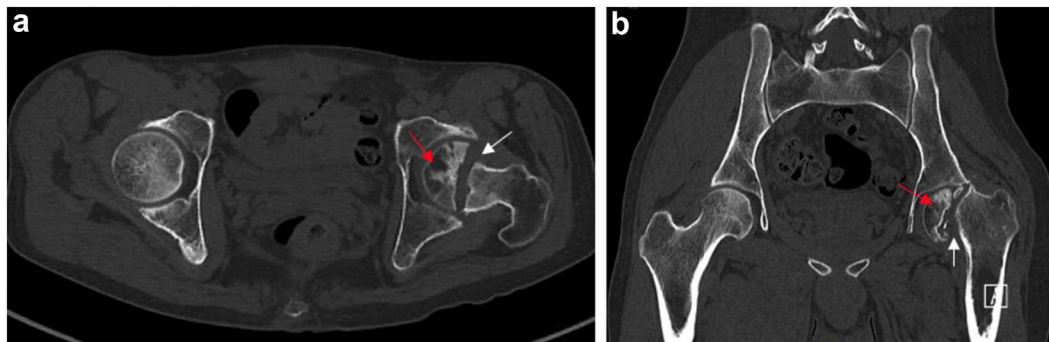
Preoperative (a) axial and (b) coronal images of CT scan two years after first ballistic injury showing femoral neck nonunion (white arrow) and avascular necrosis of the femoral head (red arrow). CT, computed tomography.
